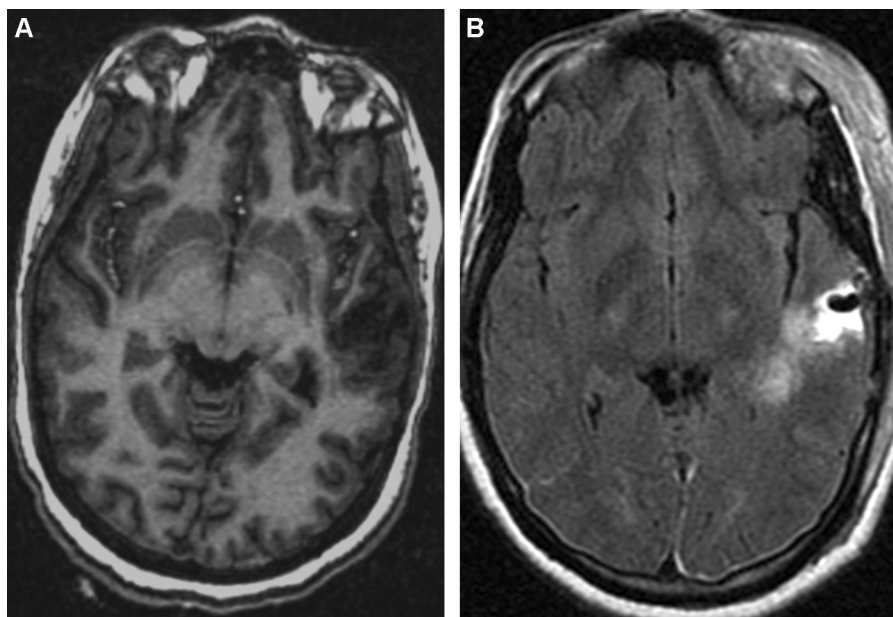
Magnetic resonance imaging. A. Preoperative axial T1-weighted gadolinium-enhanced image showing a hypointense, non-enhanced left temporal lesion. B. Postoperative axial fluid-attenuated inversion-recovery-weighted image showing a small residual tumour in contact with the left ventricle.
